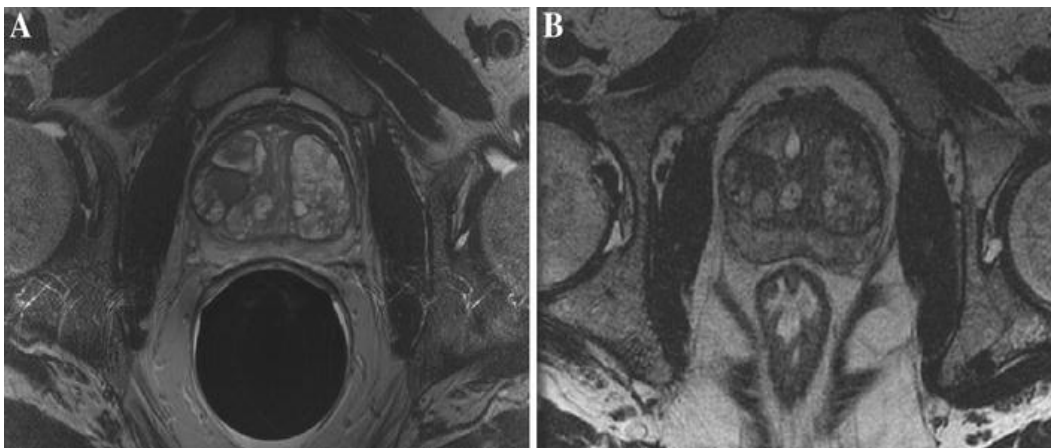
T2-weighted images demonstrating differences between acquisitions with and without ERC.
